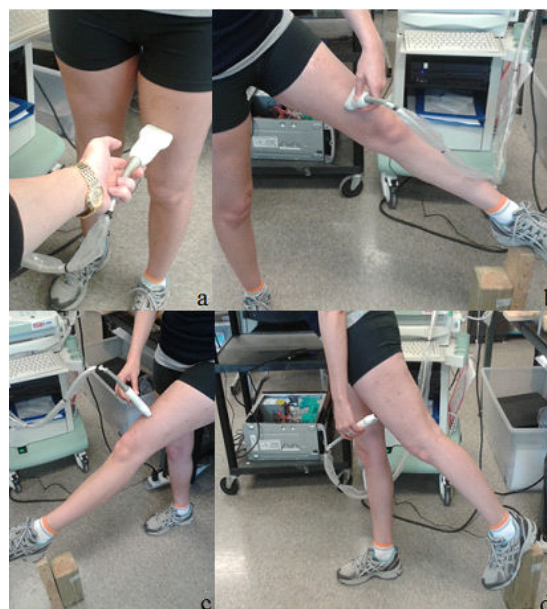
Subject positions during ultrasound depth measurements, a) Standing, b) Abduction, c) Flexion, and d) Extension
